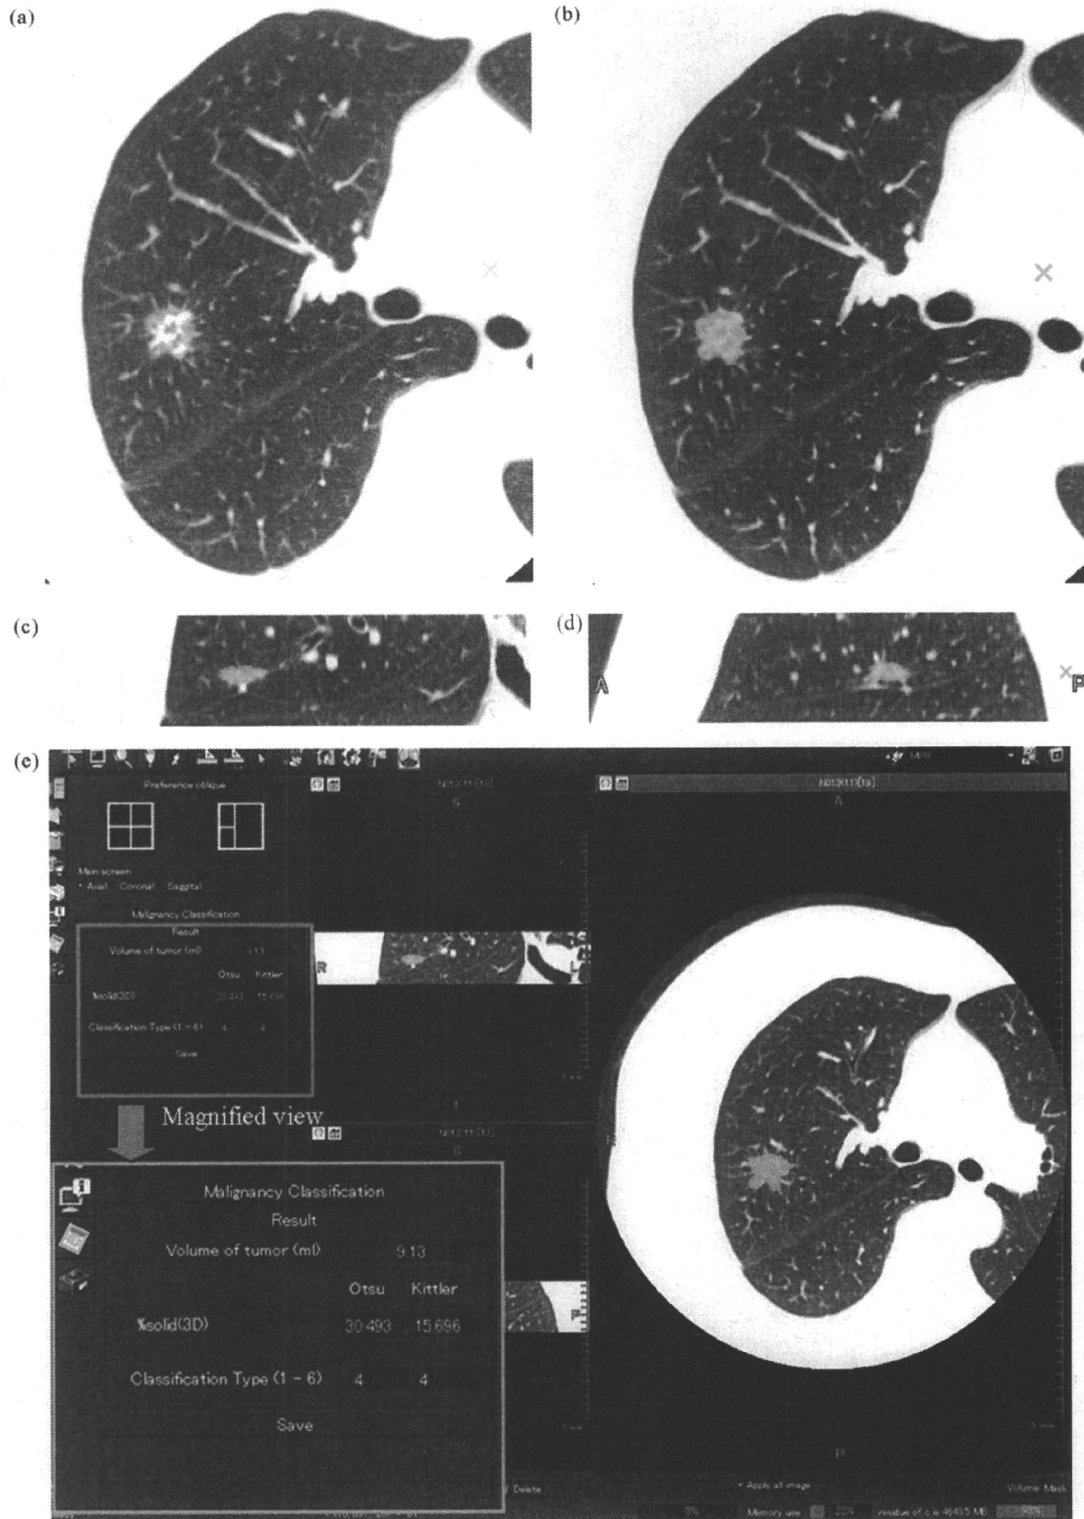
A case of type 4 tumor in a 68-year-old woman. Axial CT image (a) shows a tumor with an area that consisted of GGO and solid parts. The green areas ((b) axial CT image, (c) coronal CT image, and (d) sagittal CT image) show an extracted tumor. Overall view of our software is shown by (e). Green frame is a magnified view of red frame. Our software indicates a tumor volume of 9.13 ml: 3D%solid using Method-1 is 30.493% and using Method-2 (Kittler's method) is 15.696%. Our software classified this tumor as type 4 (mixed type with an area that consisted of GGO and solid parts that have air-bronchogram or that show a punctate distribution).
